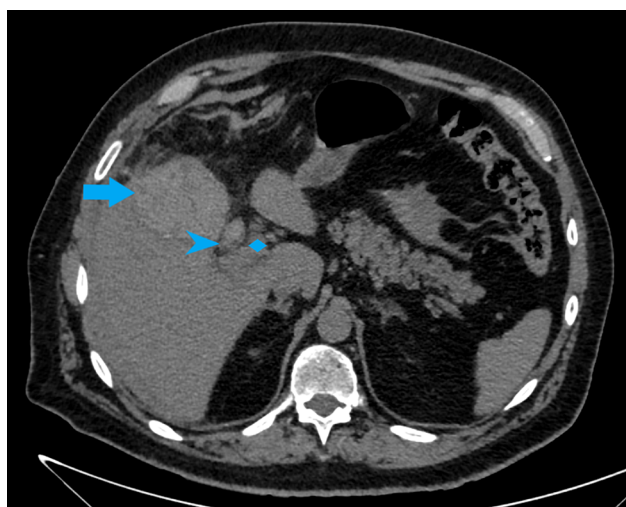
The abdominal CT on the second admission – hematoma in the gallbladder fossa (arrow), dilated common bile duct filled with blood (arrowhead) and portal vein (rhombus).
